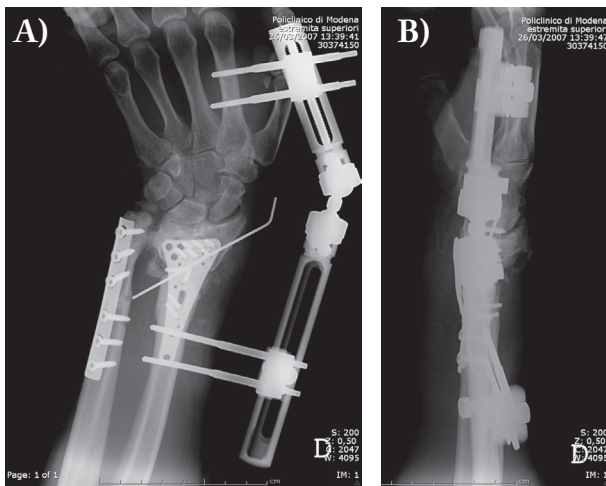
(Case 1). A) AP view X-ray post radius osteotomy with graft; B) LL view X-ray post radius osteotomy with graft
